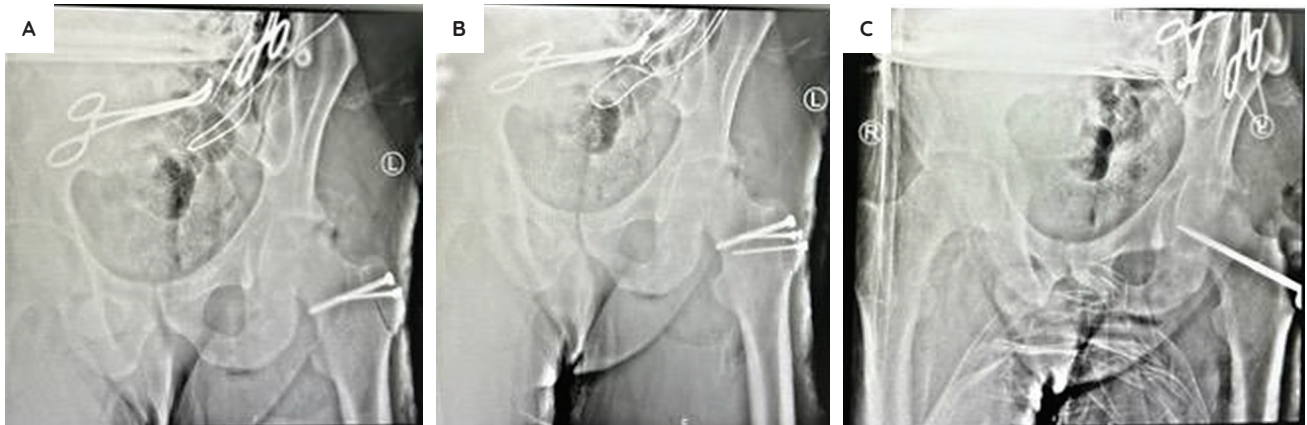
Intra-operative radiographs—Judet oblique (A), iliac oblique (B), and anteroposterior pelvic view (C)—obtained on the day of surgery, 8 weeks post-injury.
